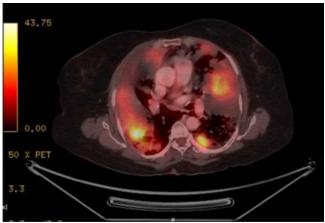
PET CT suggestive of hypermetabolic consolidatory lesions and diffuse nodular opacities in bilateral lungs – likely primary
